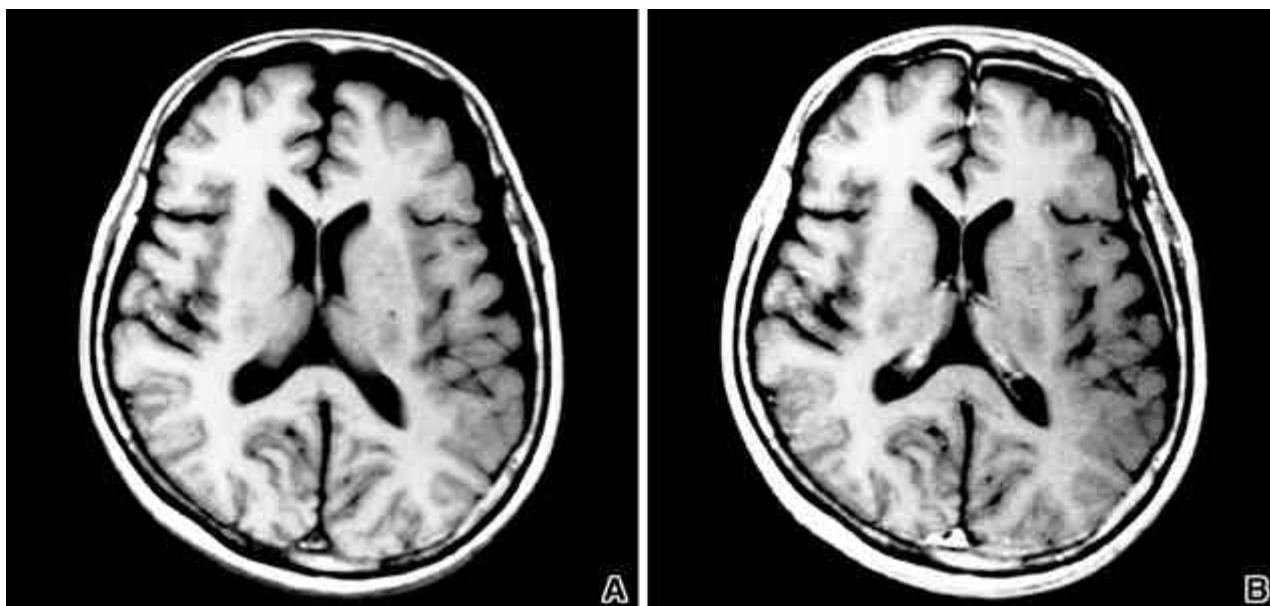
Pre (A)- and post (B)-enhanced T1-weighted MRI of a 72-year-old female on Day 13 show definite dural enhancement by Gd-DTPA.
